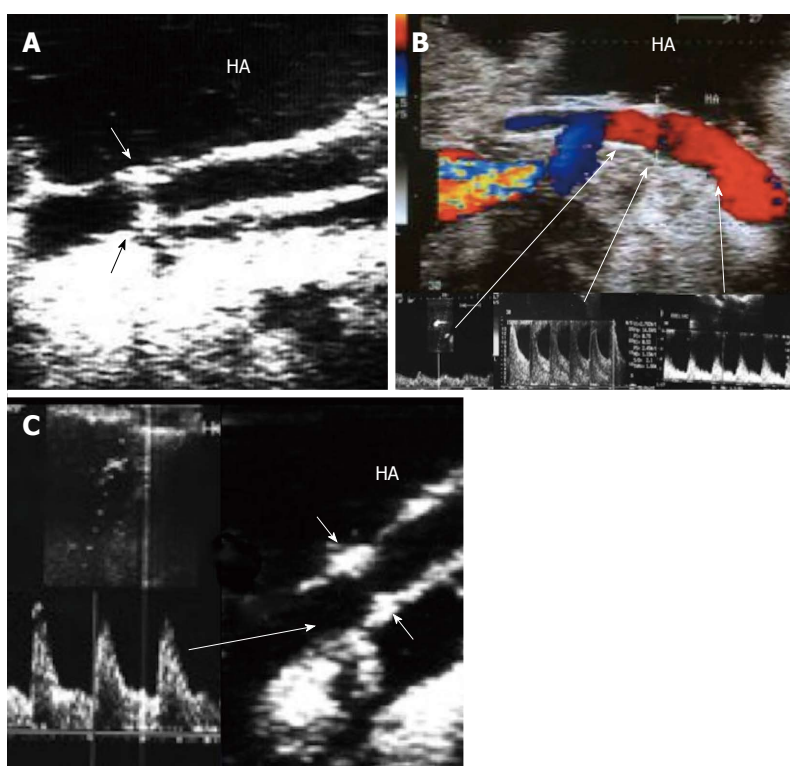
Intra-operative hepatic artery stenosis. A: IOUS B-mode image revealing significant stricture at the anastomotic site (arrows); B: Color Doppler image showing anastomotic jet of the systolic and diastolic arterial flow compared to the pre-stenotic segment and dampening of the distal flow (tardus parvus waveform); C: Doppler US image distal to the anastomosis after surgical revision, revealing improvement of the distal arterial flow with normal waveform (arrows). HA: Hepatic artery.
